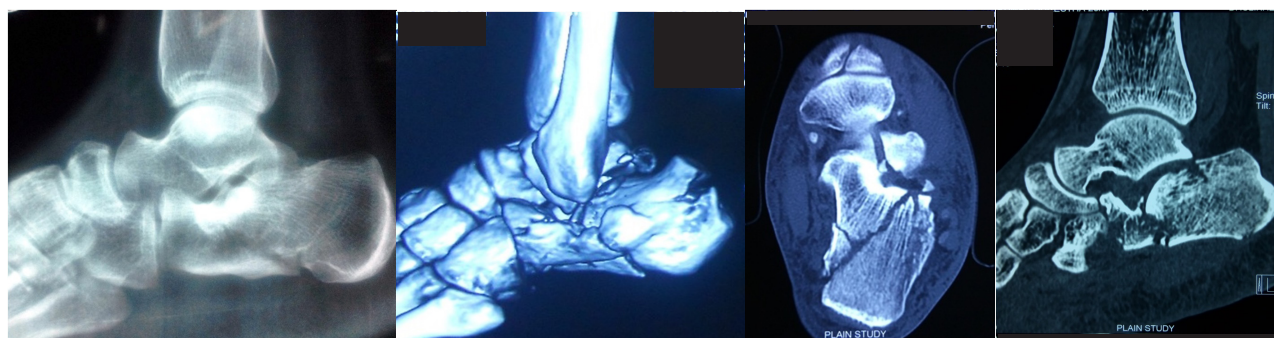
Pre operative x rays and CT scans
